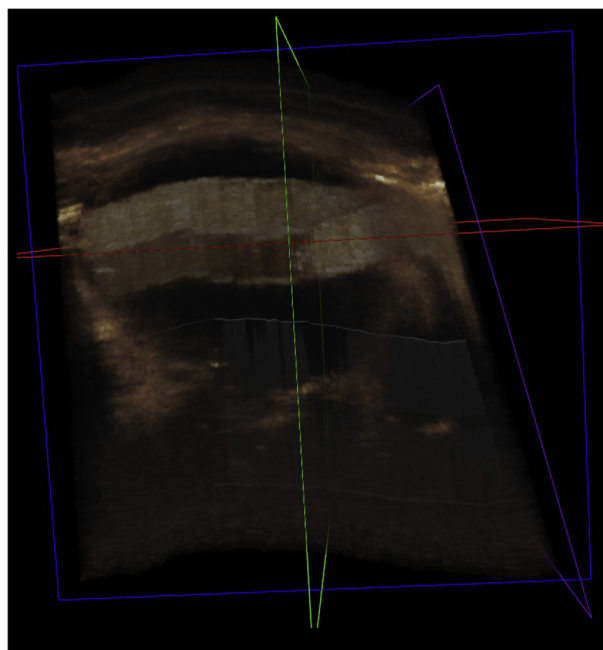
3D contrast enhanced ultrasound (3D CEUS) showing an EVAR at 2 years with no endoleak.
